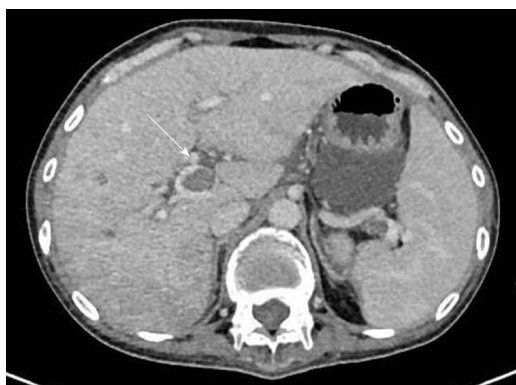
Plain computed tomography scanning and contrast enhancement of abdomen display thrombosis in the trunk of portal vein and its intrahepatic branches, the superior mesenteric vein and the splenic vein.
